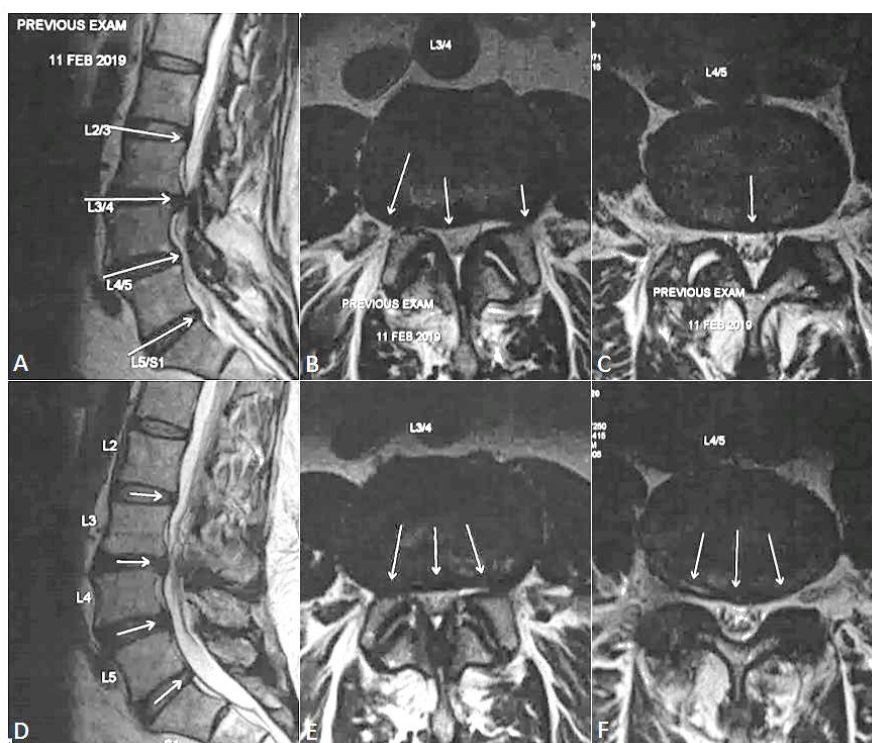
(A) Sagittal MRI image when the condition was diagnosed; (B, C) Axial MRI images when the condition was diagnosed; (D) Post-therapy sagittal improvement 11 months after the disease onset; (E, F) Post-therapy axial improvements 11 months after the disease onset
